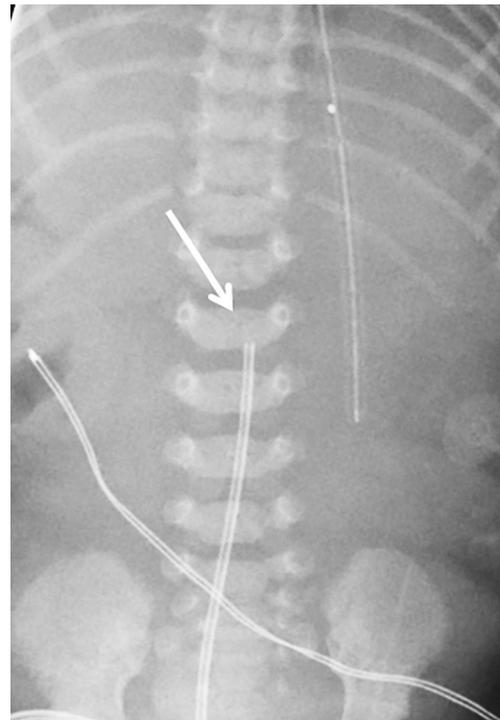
Anteroposterior radiograph of the chest and abdomen in a newborn boy. The radiology report excerpt was as follows: “Nasogastric tube, UVC and left thoracostomy tube are unchanged and in satisfactory position.” The report did not specify the location of the UVC, which is suboptimal and likely in the umbilical vein (*arrow*)
